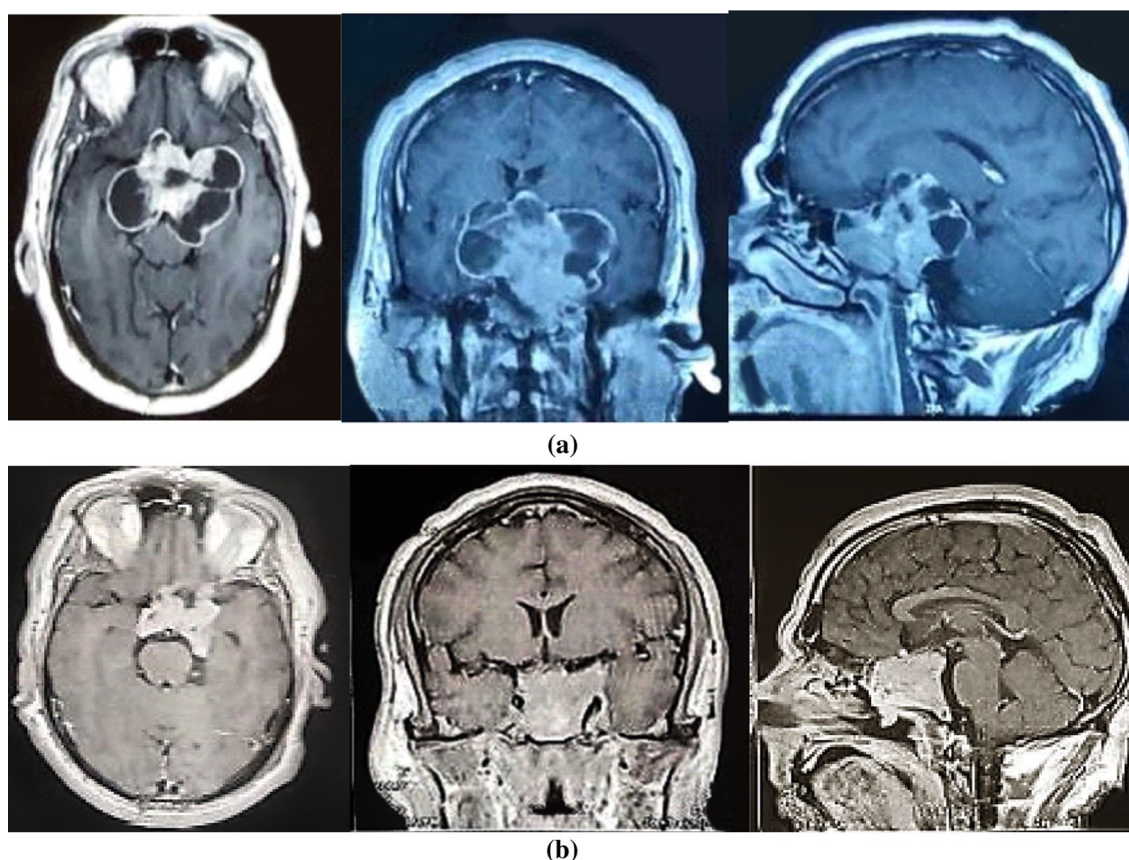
a A male patient 50 years with progressive deterioration in vision for 2 years (left eye: counting finger 25 cm, Right eye: hand movement). Preoperative post-contrast MRI brain: giant large partially cystic partially solid pituitary adenoma (3.8*7.7*5.2 cm). b Three months postoperative (transsphenoidal excision and biopsy) post contrast MRI brain: optic chiasm was decompressed, tumor burden was reduced and vision was improved (Left eye: counting finger 1 m, Right eye: counting finger 50 cm)
